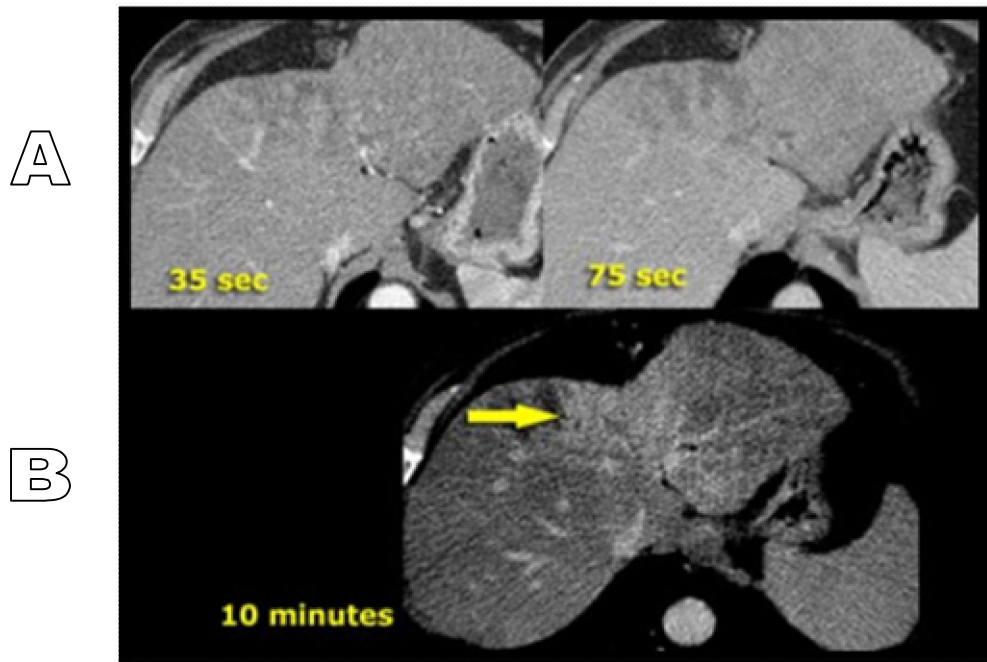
Axial triphasic CT images of the liver show irregularly enhanced hypovascular mass in the late arterial and late portal venous phase (A), a relative dense structure is seen centrally on the delayed images (yellow arrow) that loses its contrast slower than the normal liver. This indicates that the principal component of this tumor is fibrous tissue (B). This fibrous tissue also reacts to the liver capsule. The findings of these images are very suggestive of a cholangiocarcinoma ⁽³⁰⁾
